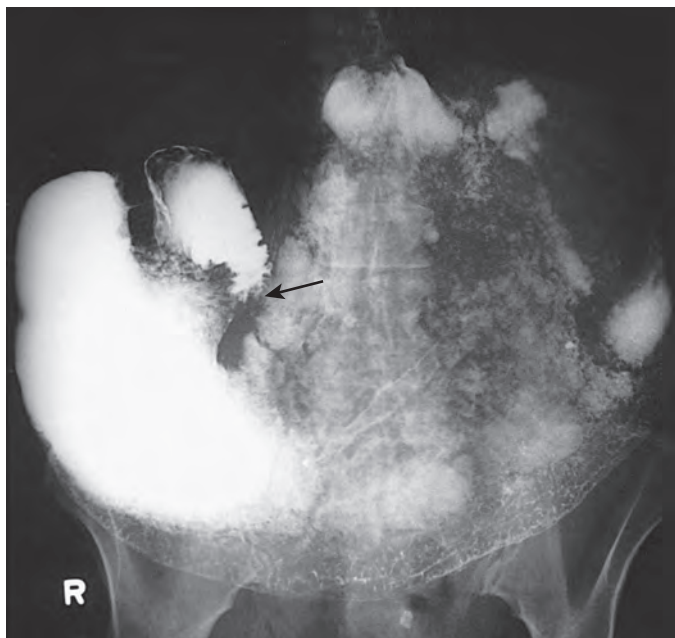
Duodenal obstruction by retroperitoneal metastases. Delayed overhead radiograph from an upper gastrointestinal study shows abrupt narrowing of the descending duodenum (arrow) with massive gastric dilation out of proportion to the degree of duodenal dilation. The dilated stomach extends inferiorly into the pelvis. (From Shammash JB, Rubesin SE, Levine MS: Massive gastric distention due to duodenal involvement by retroperitoneal tumors. *Gastrointest Radiol* 17:214–216, 1992.)
